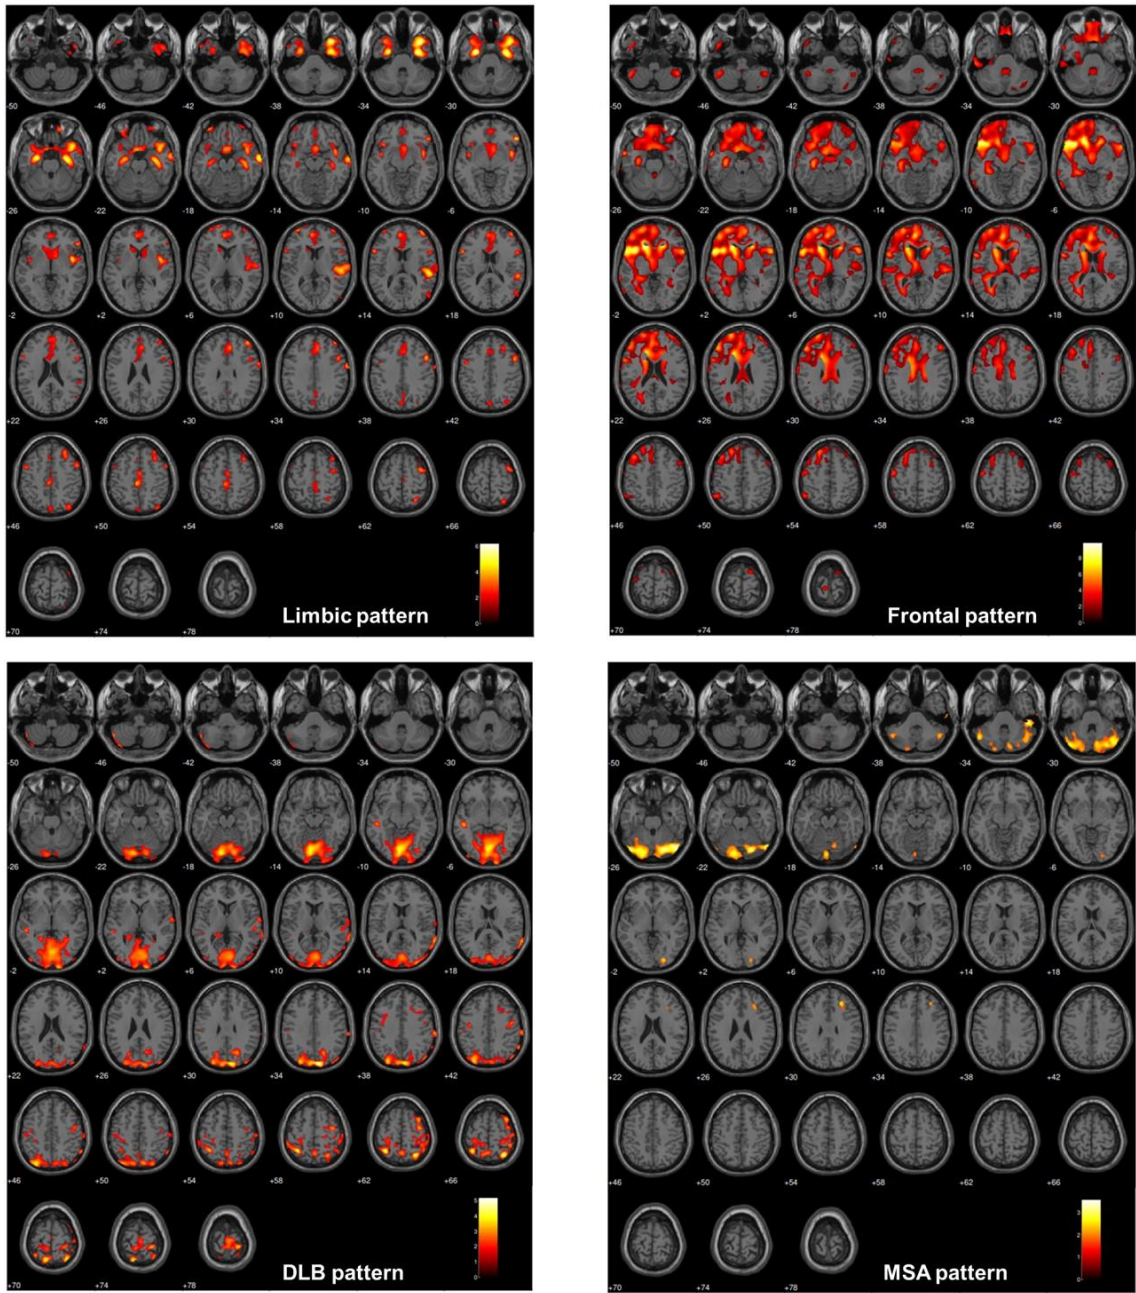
Examples of single-subject [¹⁸F]FDG-PET SPM maps in Mild Cognitive Impairment individuals.
